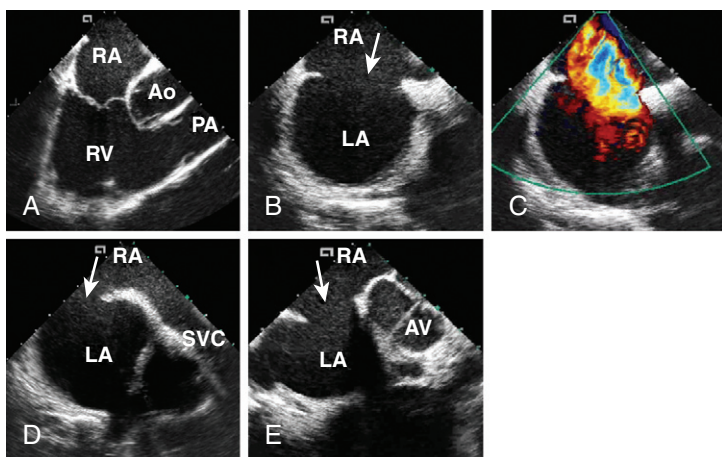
Intracardiac echocardiographic images in a patient with a large secundum atrial septal defect (ASD). A, Home view demonstrating the right atrium (RA), tricuspid valve, right ventricle (RV), aortic root (Ao) and pulmonary artery (PA). B, Septal view, demonstrating the large ASD (arrow), the RA and the left atrium (LA), and the superior and inferior rims. C, Same view with color Doppler. D, Caval view demonstrating the entire superior rim and the defect (arrow). E, Short-axis view demonstrating the defect (arrow), the aortic root, the absent anterior rim and good posterior rim, and both atria. AV, aortic valve SVC, superior vena cava.
